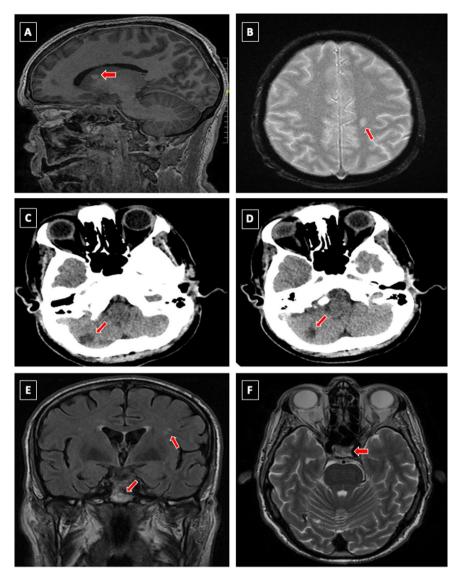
Imaging modalities performed on the patient. (A) Sagittal MRI of the brain demonstrating ischemic lesions. (B) Axial MRI of the brain demonstrating ischemic lesions. (C) CT scan of the brain revealing hypodensity in the cerebellar hemisphere, indicative of necrosis. (D) CT scan of the brain revealing hypodensity in the cerebellar hemisphere, indicative of necrosis. (E) Frontal MRI of the pituitary gland demonstrating necrosis and ischemic lesions. (F) Axial MRI of the pituitary gland demonstrating necrosis.
